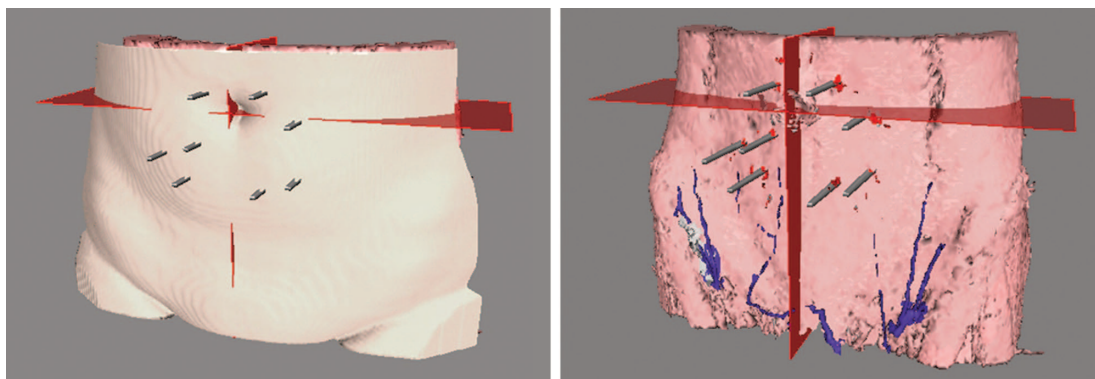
Three-dimensional abdominal wall reconstruction with VirSSPA software from computed tomographic angiography images. (Left) Emergence of multiple perforators from the anterior rectus sheath and through the abdominal skin located with *gray posts*. (Right) Perforators and their course through the muscle without the skin envelope. The superficial inferior epigastric system is marked in *blue*.
